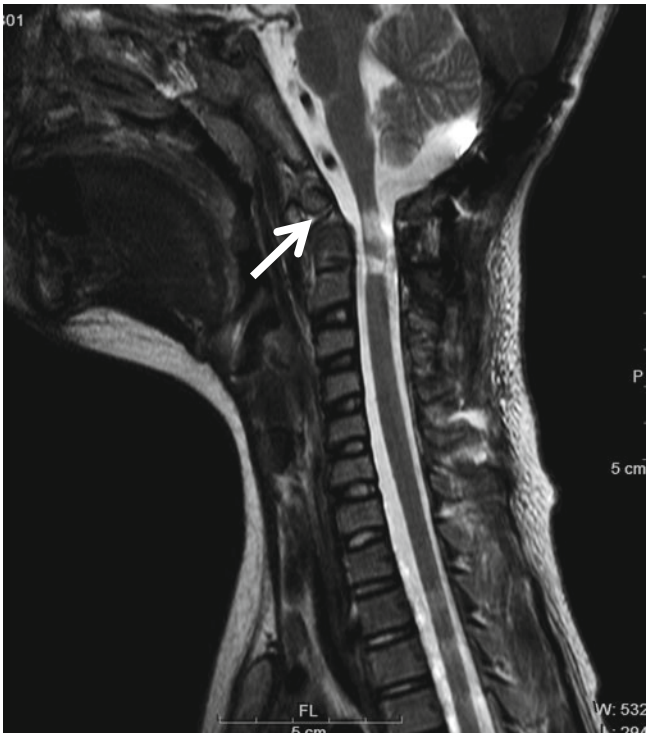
Upper cervical injury in a 13-year-old boy. T2-weighted sagittal image shows fracture at the synchondrosis (*arrow*) between the dens and C2 body. Upper cervical cord at the same level is hyperintense and atrophic
